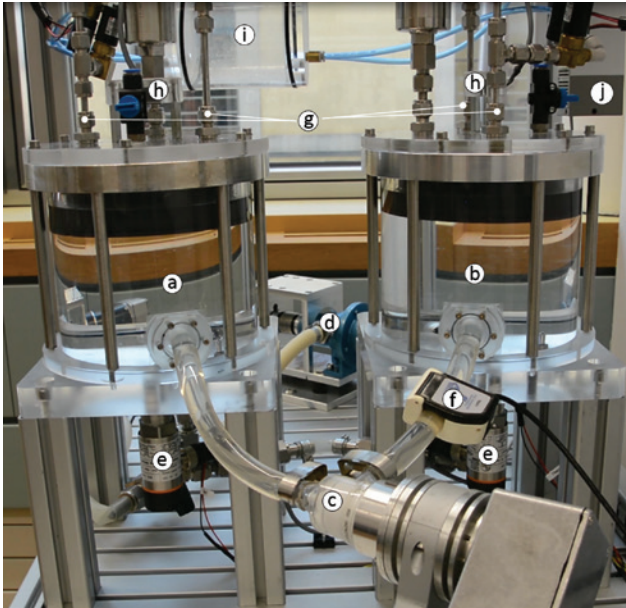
Picture of the hardware part of our hybrid mock circulation consisting of two pressure-controlled reservoirs (a) and (b), a blood pump head (Deltastream DP2, Xenios AG, Heilbronn, Germany) (c) equipped with an encoder (ME22, PWB Encoders GmbH, Eisenach, Germany) and an industrial motor controller (Accelus, ASP-090-09, Copley Controls Corp., Canton, MA, USA), a backflow pump (Moyno 500 Pumps-200 Series, Moyno, Inc., Springfield, OH, USA) (d), two fluid-pressure sensors (PN2009, IFM Electronic GmbH, Essen, Germany) (e), one ultrasonic flow probe (TS410/ME-11PXL, Transonic Systems, Inc., Ithaca, NY, USA) (f), one proportional solenoid inlet valve (PVQ33-5G-23-01F, SMC Pneumatics, Tokyo, Japan) and two proportional solenoid outlet valves (PVQ33-5G-40-01F, SMC Pneumatics, Tokyo, Japan) per reservoir (g), two fluid-level sensors (GP 2Y0D810Z0F, Sharp, Osaka, Japan) (h), a vacuum receiver (i) and a vacuum pump (ZL112-K15L0UT-E26L-Q, SMC Pneumatics, Tokyo, Japan) (j).
